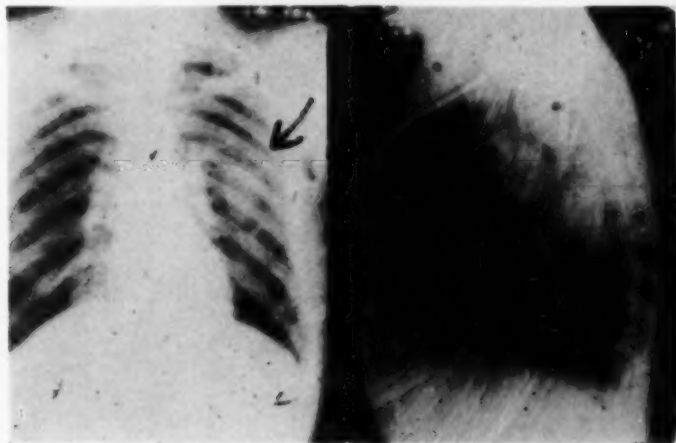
Left: X-ray of patient. Right: Abscess apex cavity, left lower lobe.
